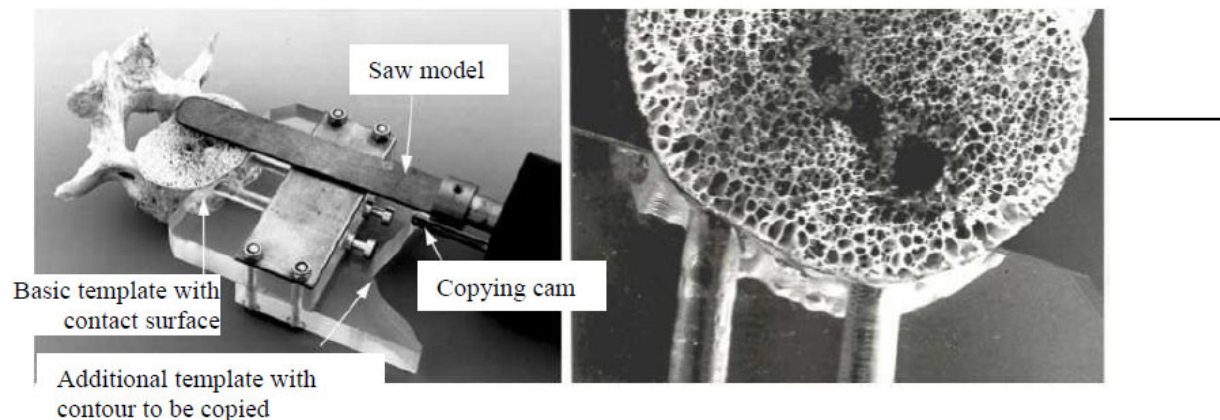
Ventral vertebral body osteotomy with depth-of-cut limitation: a) template and vertebral bone after osteotomy has been performed using the model of a TUKE saw with copying cam (the additional parallel guide was dismantled for display reasons). The contour to be copied and copying cam limit the movement of the tip of the saw blade exactly to the dorsal surface contour of the vertebral body; b) detailed image of the osteotomy plane showing the contact between CT-image-based base template and bone
